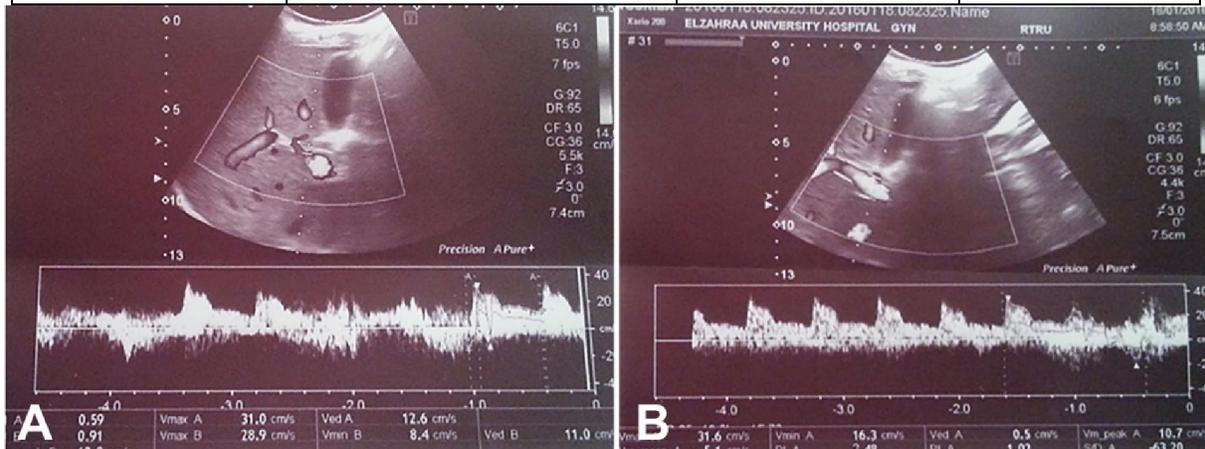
a) Color Doppler ultrasonography of hepatic artery in pregnant women 30 weeks of gestation with normal blood pressure shows normal RI: 0.59 and normal PI:0.91. b) Color Doppler ultrasonography of hepatic artery in pregnant women 33 weeks of gestation with HELLP syndrome shows elevated RI: 1.0., and elevated PI: 2.84.
